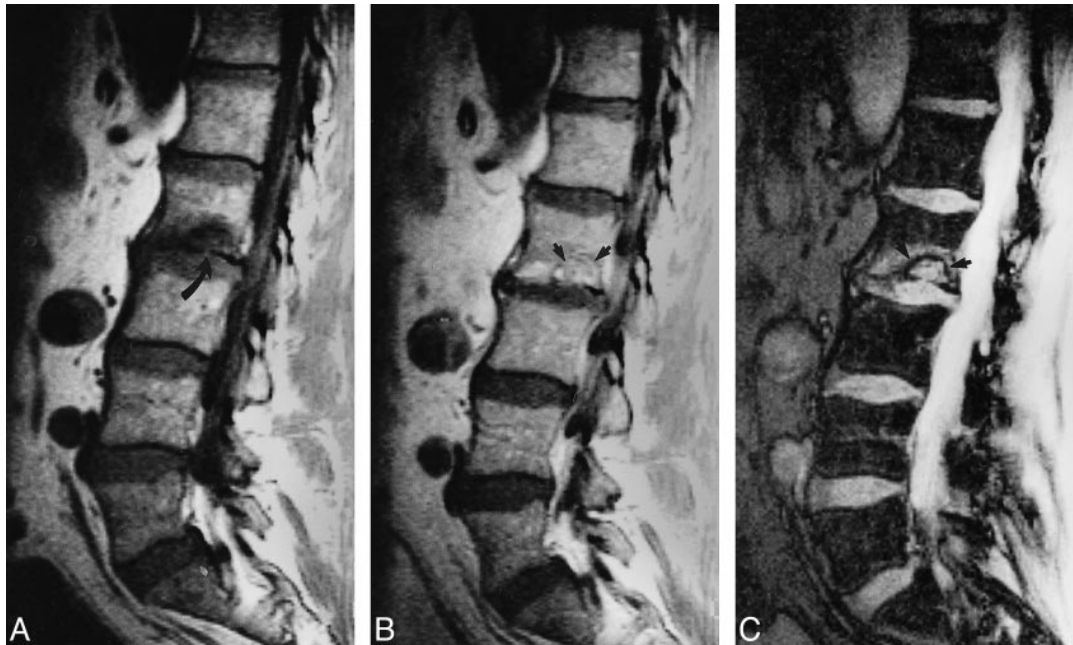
MR images obtained 6 days after injury of a 38-year-old man who experienced the sudden onset of pain and point tenderness referable to the L2 level immediately after experiencing axial-loading injury.
